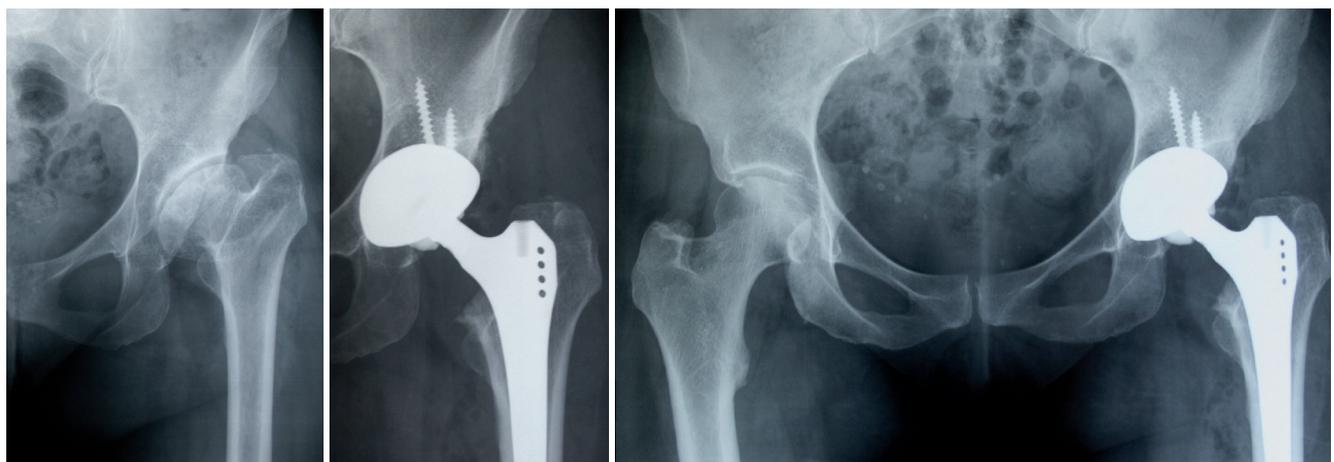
Female patient with dysplastic coxarthrosis Crowe II, from left to right: preoperative X-ray image, postoperative X-ray image, X-ray image 2 years postoperatively (  Tikhilov)
